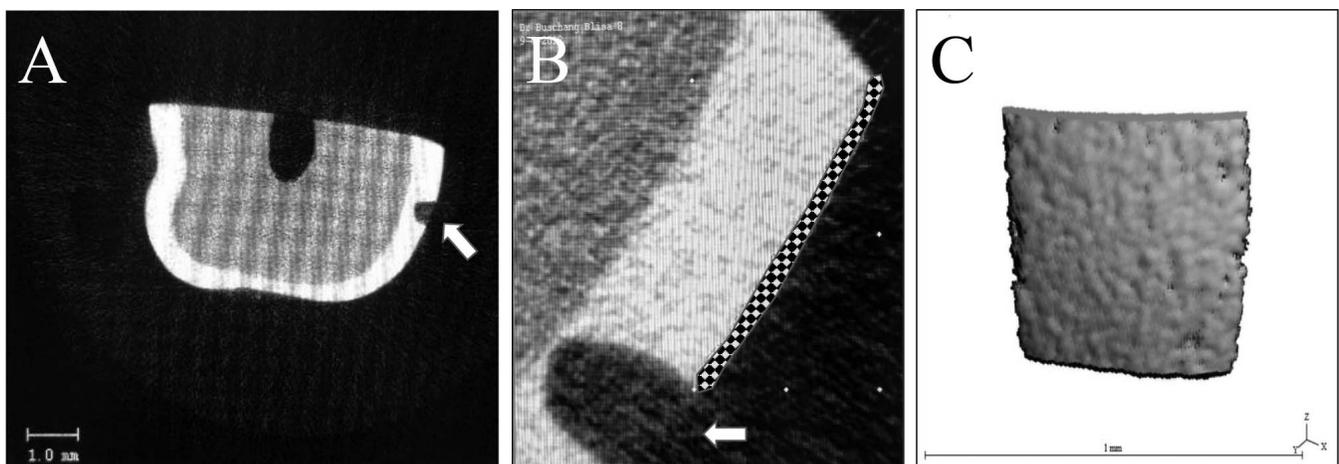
μ CT (A) cross-sectional scan showing notch (white arrows), (B) region of interest selection (checkered), and (C) three-dimensional reconstruction of region of interest for density calculations.
